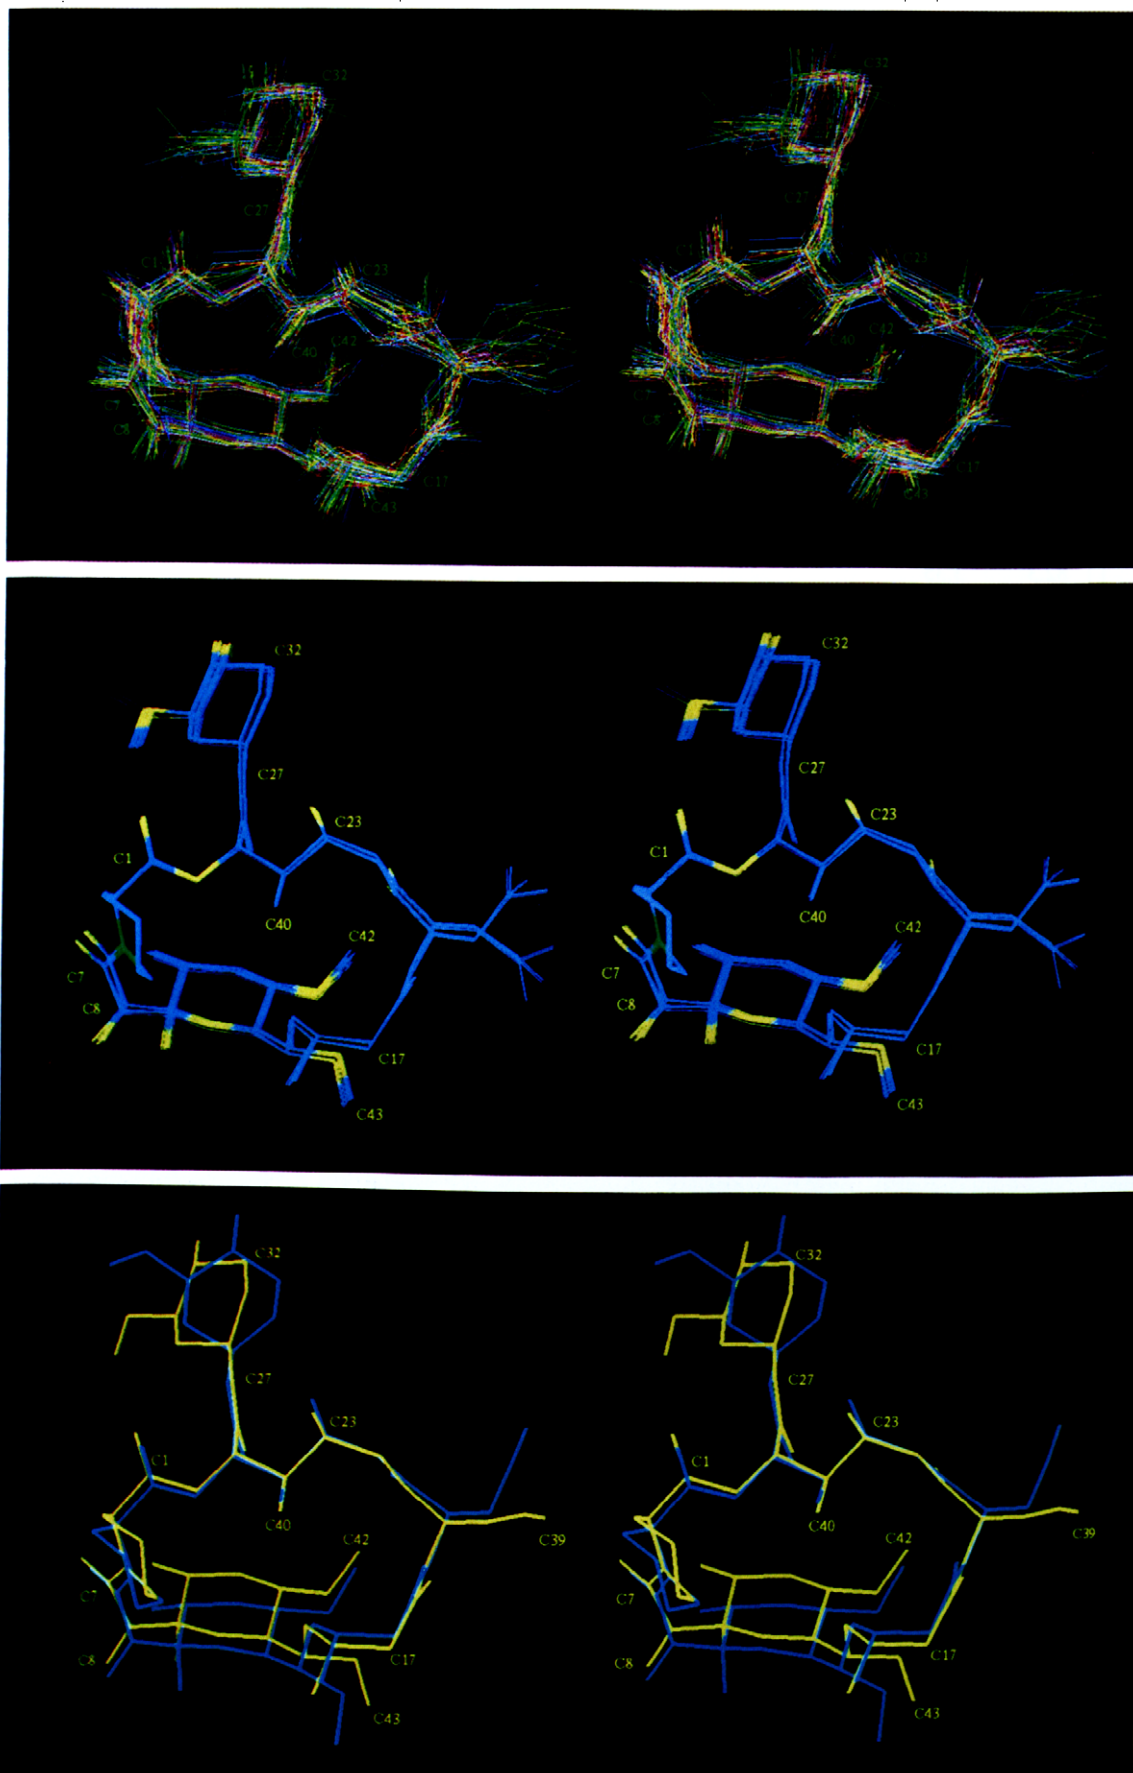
(top) Stereoview of the 50 DGII structures with the lowest total error functions. Only heavy atoms are shown. (middle) Stereoview of the 39 MD-refined NMR structures with the lowest total energies and *trans* amide configurations. Heavy atoms are coded: carbon (blue), oxygen (yellow), nitrogen (green). (bottom) Stereoview of the average NMR structure (yellow) superimposed upon the X-ray structure (cyan) of reference [11]. Only heavy atoms are shown.
